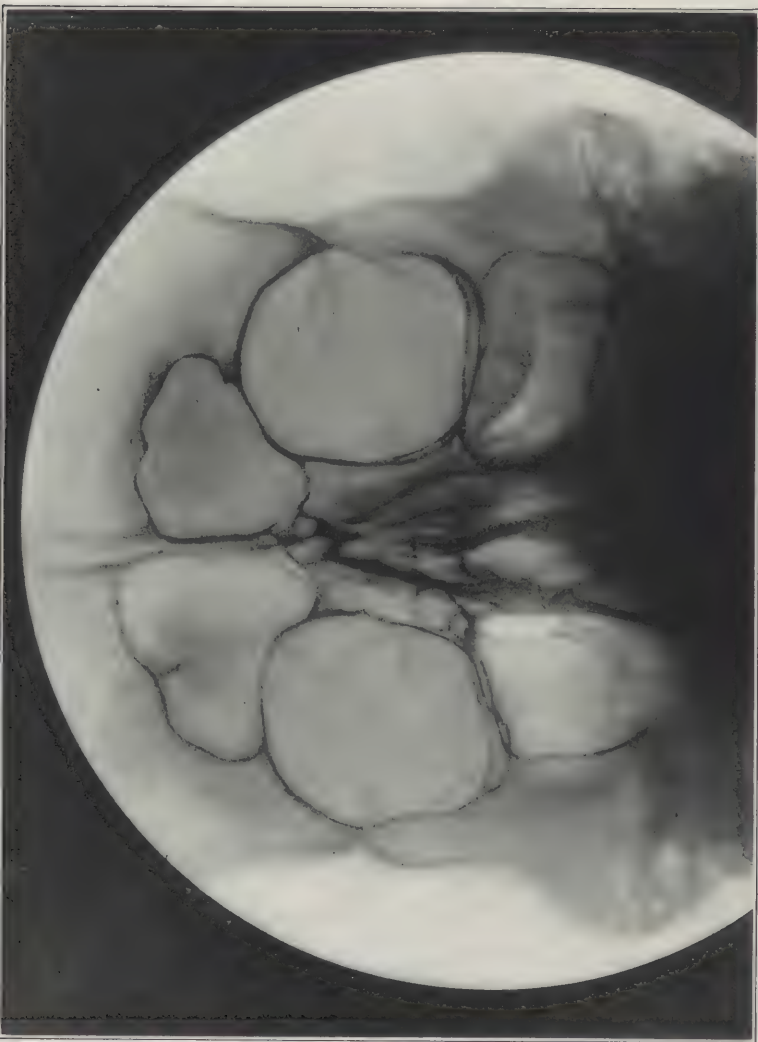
This X-ray plate shows large frontal sinuses, with broad floors leading to the anterior ethmoids. The ethmoidal capsules are well outlined and show their connection with the antra. The right antrum is narrow and high, while the left is broad and shallow. The thin plates of bone between the frontal sinuses, the ethmoidal capsules, and the antra and orbits are very clearly shown.
